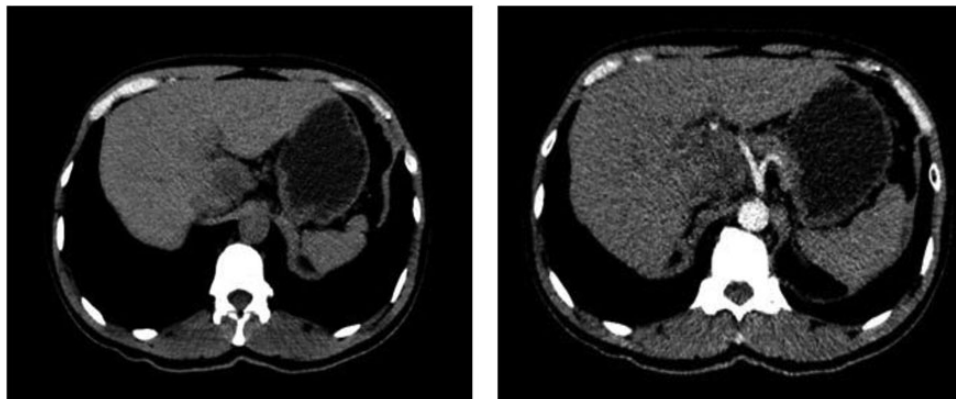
CT scan showed a large lesion arise from the caudate lobe (Case 3).
